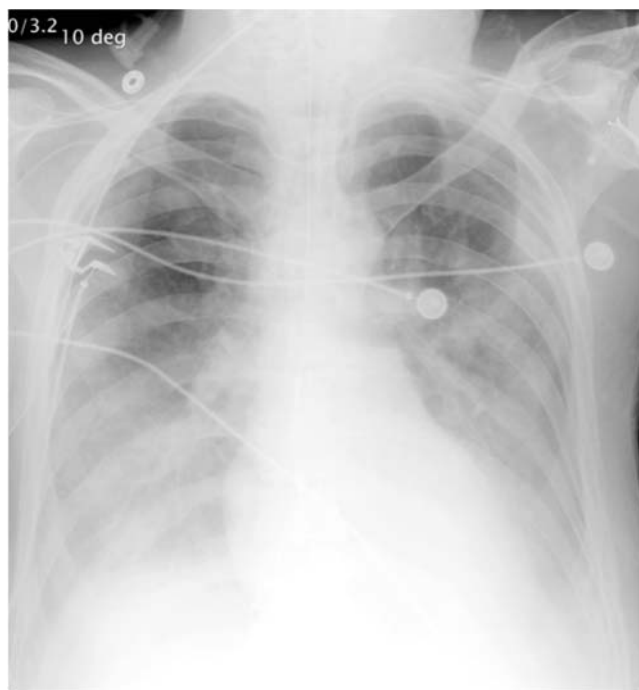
Supine chest radiograph of a patient with bilateral pleural effusion shows increased homogeneous density of the lower hemithoraces.
